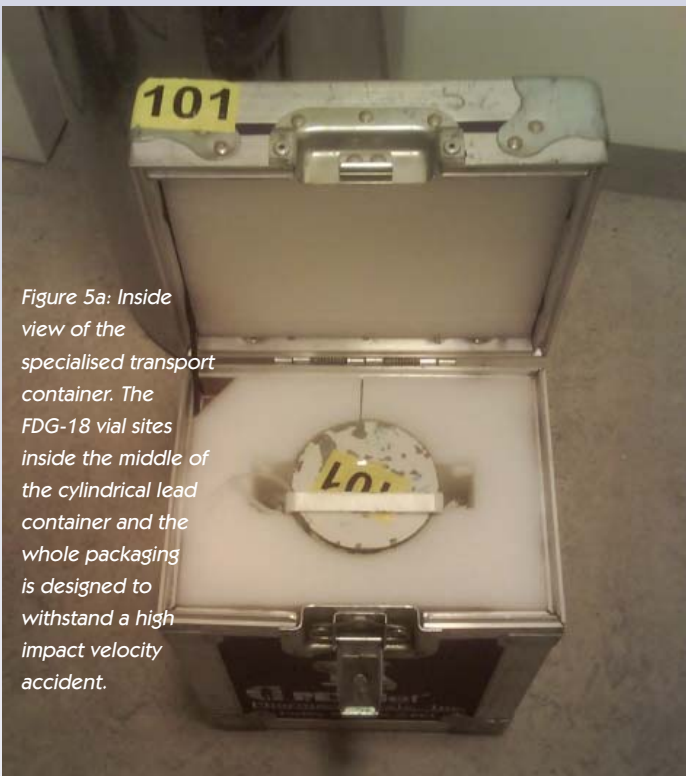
Inside view of the specialised transport container. The FDG-18 vial sites inside the middle of the cylindrical lead container and the whole packaging is designed to withstand a high impact velocity accident.
